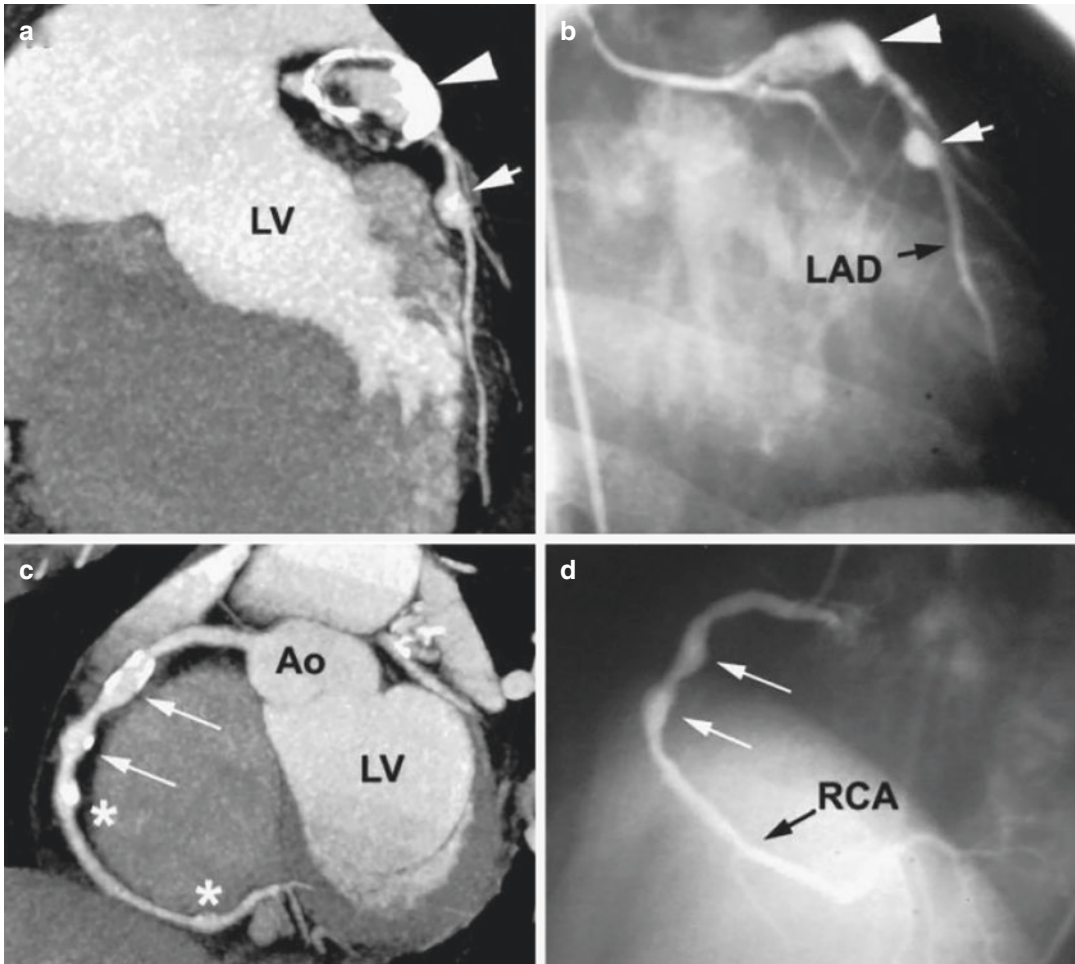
(a) Multi-slice computed tomographic angiography of the left anterior descending artery reveals a giant aneurysm (large arrowhead) with calcified wall (high density area), thrombi (the low density area inside). A distal smaller aneurysm was also noted (small arrowhead). (b) Corresponding catheterized coronary angiography.
